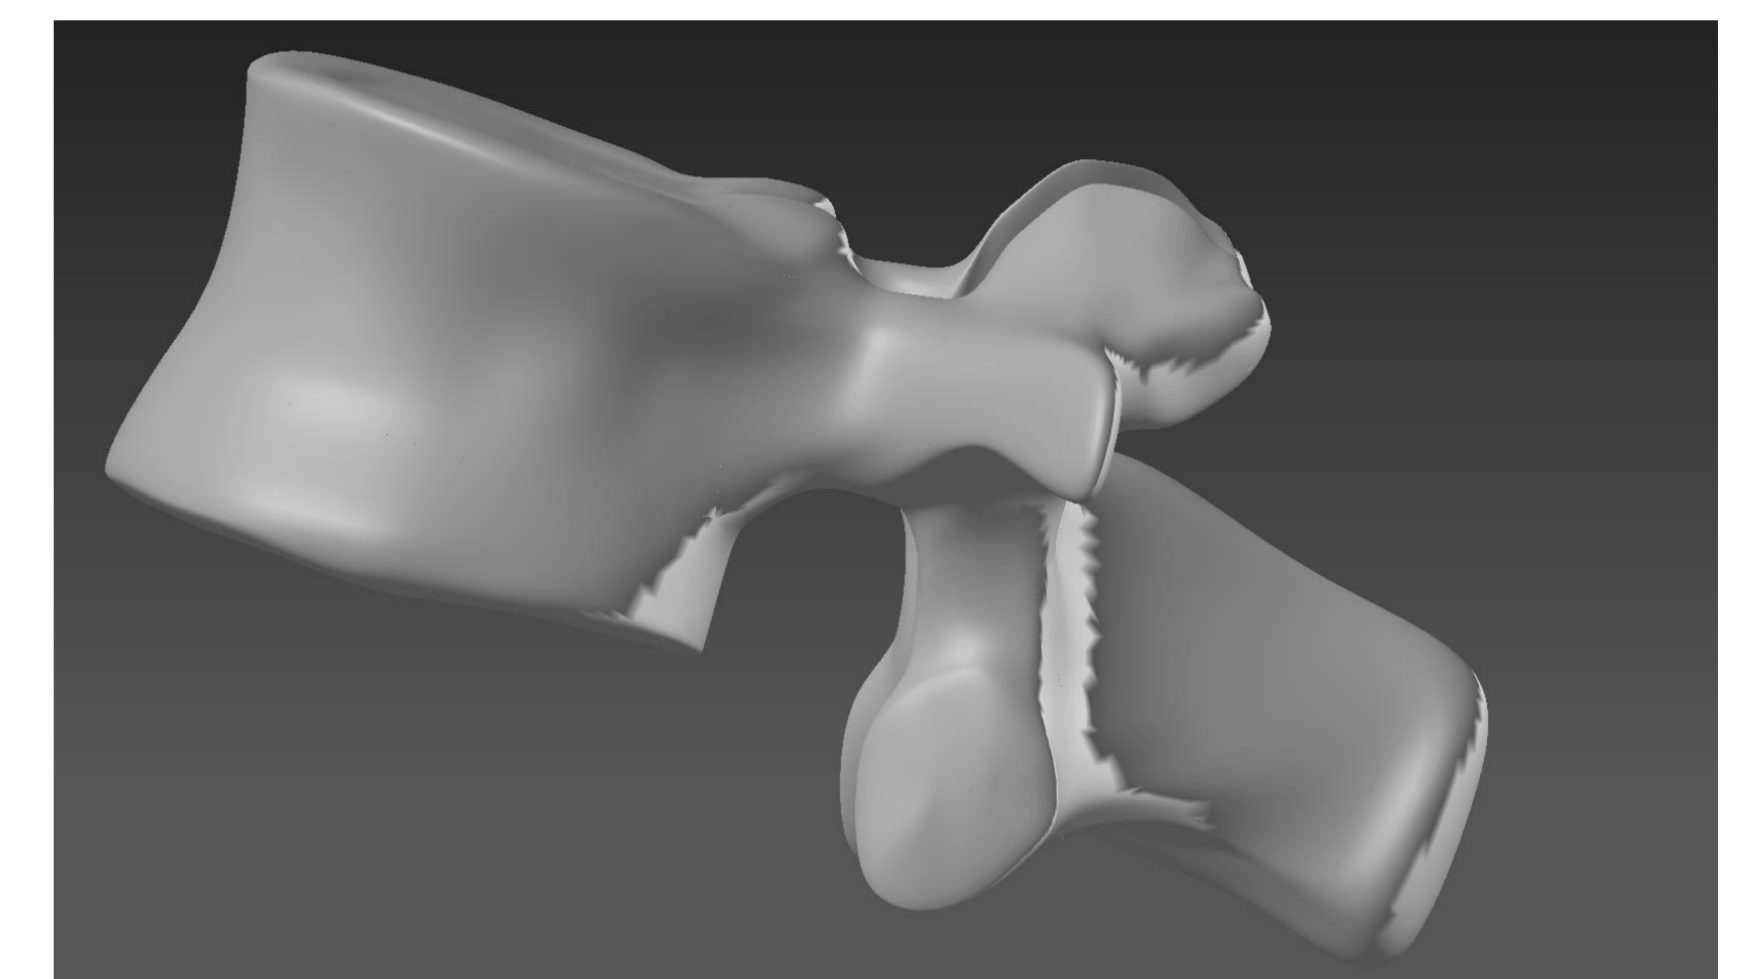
Three-dimensional normal lumbar vertebra model reconstructed from segmentation CT images (L1 vertebra). Biomechanical analysis of a single vertebra will be performed before whole spine analysis. Three-dimensional vertebrae model with metastases, osteoporosis and healthy bone from CT images segmentation will be performed.
